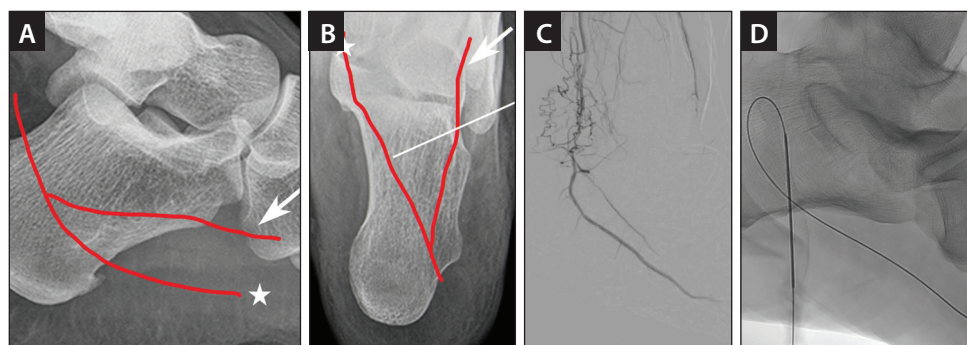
Lateral radiograph of the foot, with red lines indicating the course of the lateral (white star) and medial (arrow) plantar artery (A). Anteroposterior radiograph of the foot, with red lines indicating the course of the lateral (white star) and medial plantar artery (arrow) and white line indicating the projected needle path with a medial access. Note the entry perpendicular to the lateral plantar artery and the more favorable shallow entry angle into the medial plantar artery (B). Digital subtraction angiogram of left foot in lateral projection showing occlusion of the distal PT artery and proximal common plantar artery. The medial plantar artery is relatively small and outflow to the forefoot is mainly through the lateral plantar artery (C). Fluoroscopic image (same patient as Figure 1C) with needle in medial plantar artery and wire into the lateral plantar artery to facilitate positioning of pedal access set (wire purchase maneuver) (D).
